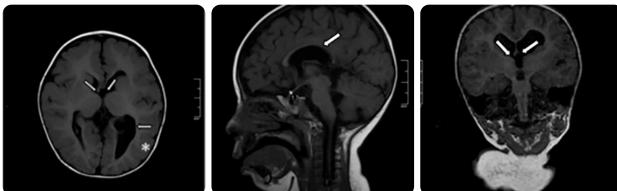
14-month-old patient with prenatal diagnosis of mild ventriculomegaly. MRI axial slice T2 FLAIR*. a) Axial plane: absence of bilateral fornix (upper arrows), colpocephaly (horizontal arrow), continuity of interhemispheric fissure with the ventricular system and ventriculomegaly of left predominance. b) Sagittal plane: dysgenesis of the corpus callosum. c) Coronal plane: bilateral absence of fornix.
